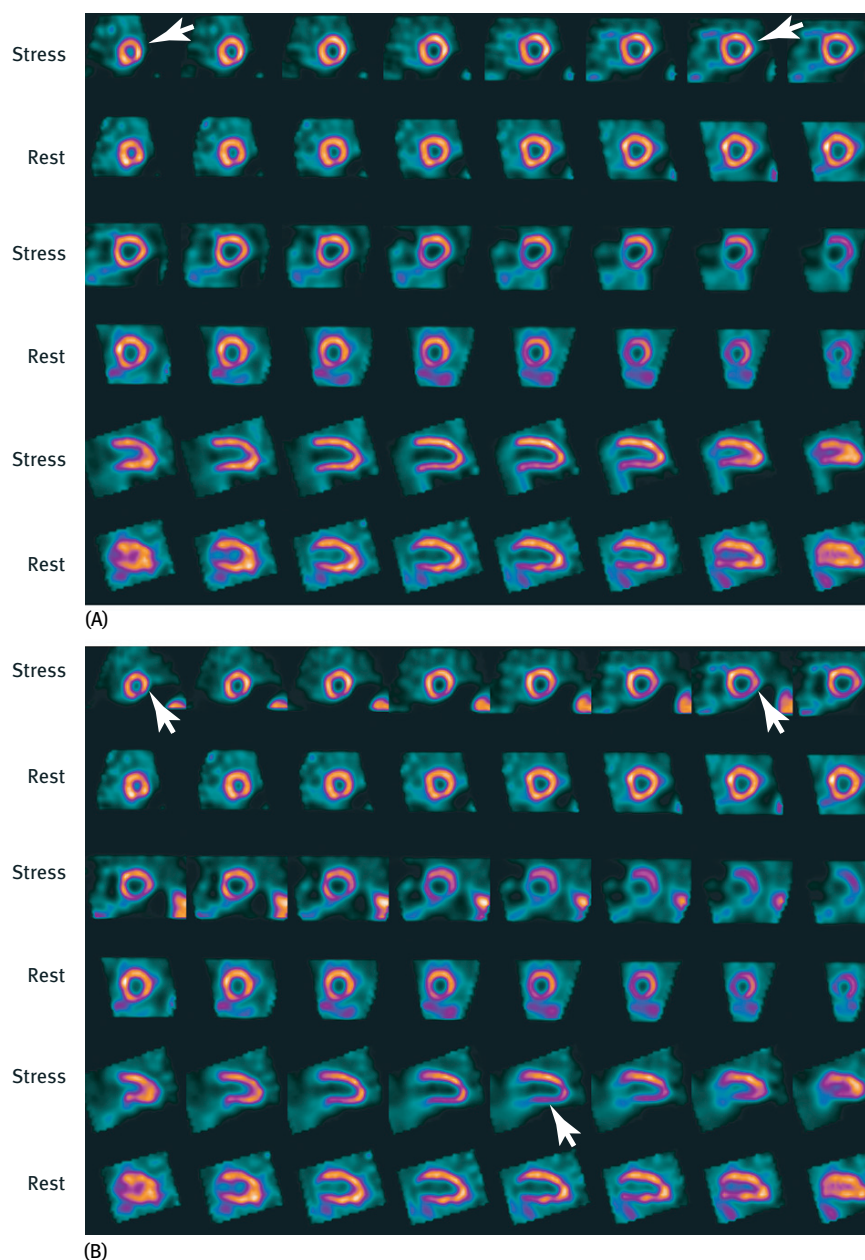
Tc-99m-sestamibi SPECT MPI performed with the D-SPECT camera: (A) 70 minutes post-stress showing perfusion defects (white arrows) in the apical segments of the left ventricle and the apex; (B) 8 minutes post-stress showing exercise-induced perfusion defects (white arrows) in the apical segments of the left ventricle and the apex as well as in the inferolateral and inferior walls of the left ventricle. The latter defects are not present at rest and on images acquired 70 minutes post-stress.
